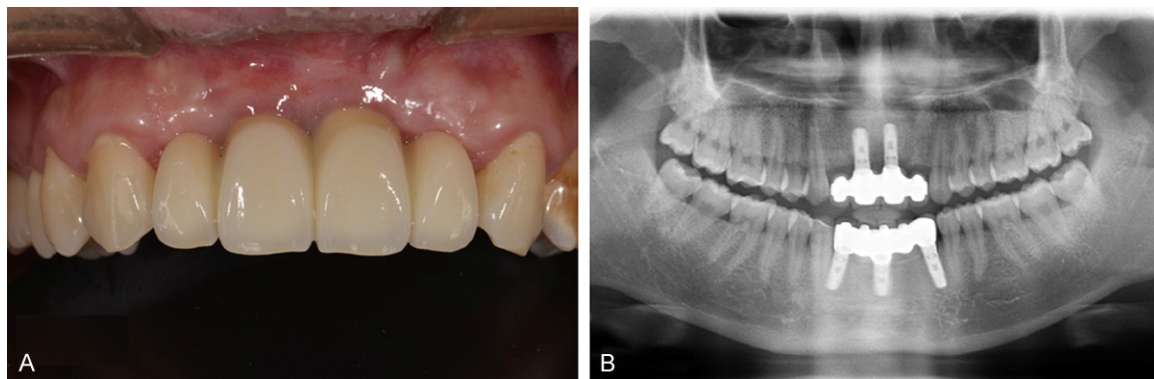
A. Thirteen months after implants placement. B. Thirteen months after implants placement, panoramic radiographs revealed good osseointegration with no bone resorption around implants.
